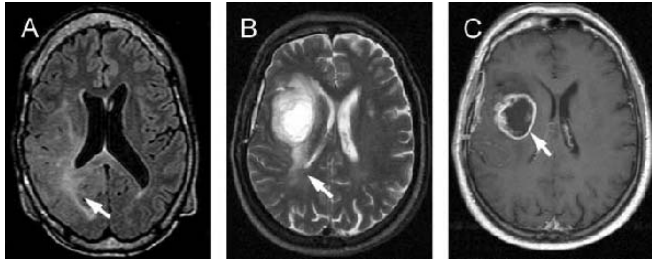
Anaplastic astrocytoma (AA; World Health Organization [WHO] grade III) and glioblastoma (GBM; WHO grade IV) have distinct growth patterns as demonstrated on magnetic resonance imaging (MRI). (A) Axial MRI of AA shows expansion of the involved brain and increased signal intensity on FLAIR imaging, reflecting the vasogenic edema that arises in response to infiltrating tumor cells (arrow). After the administration of contrast agents, most AAs demonstrate modest or no enhancement resulting from an intact blood–brain barrier and a lack of central necrosis. (B) Axial MRI of GBM also demonstrates hyperintense regions at the tumor periphery on T2-weighted imaging, indicative of diffusely infiltrating cells (arrow). (C) A distinguishing feature is the emergence of a central contrast-enhancing component, which contains a necrotic center and a leading edge that rapidly expands outward (arrow).
